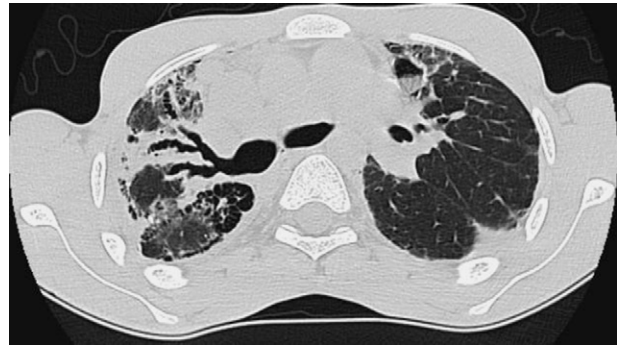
Severe lung disease following HCT as seen on high-resolution CT scan. Note both bronchomegaly and bronchiectasis, seen best in the right upper lobe. Additional findings include widespread fibrosis of the right upper lobe and lingula, with relative sparing of the left lower lobe; pleural thickening is present bilaterally.
